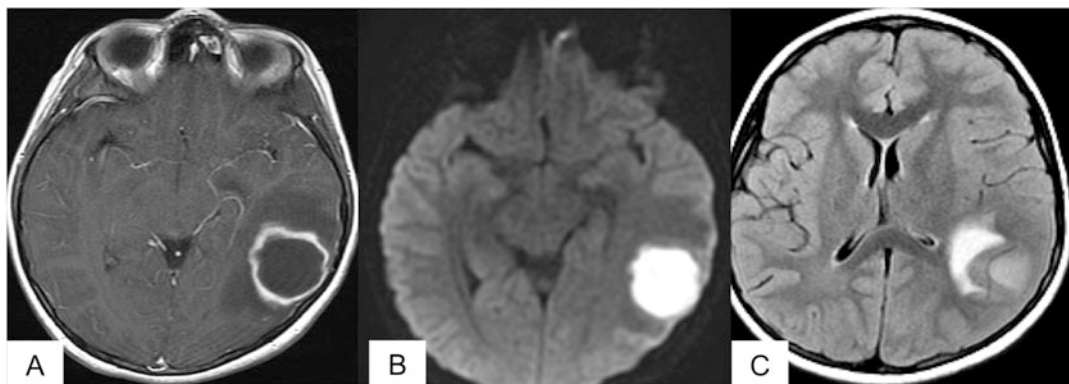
Cerebral abscess. An ovoid ring-enhancing (a) left parietal lesion demonstrating internal restricted diffusion on DWI (b) with surrounding vasogenic edema on T2W FLAIR (c) was identified in this 6-year-old boy
